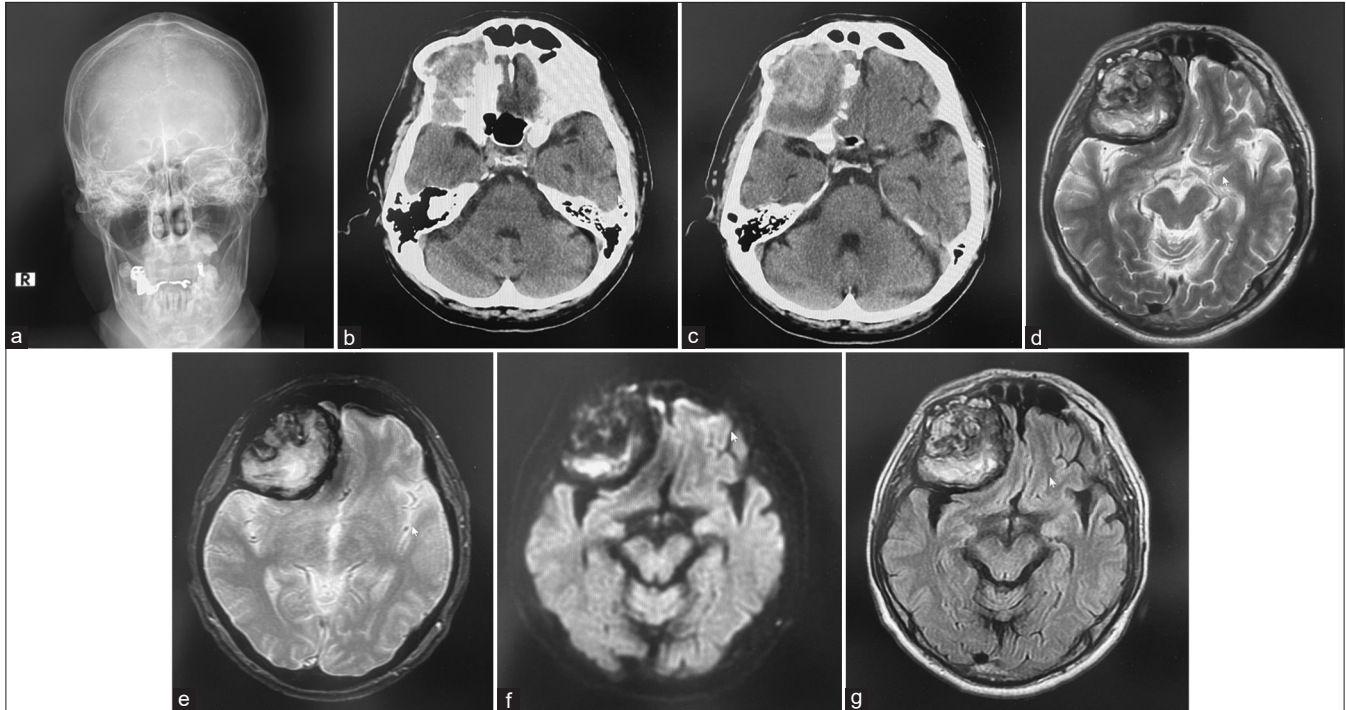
(a) Plain craniogram showed the destruction of the upper rim of the right orbit and the right sphenoid wing. (b and c) Brain plain CT examined in outpatient clinic revealed the mixed density lesion with partial high density and the right frontal skull-base destruction. (d) Brain plain magnetic resonance imaging (MRI) disclosed well-demarcated tumor-like lesion with heterogeneous mixed intensity in T2-weighted image, (e) Brain plain MRI disclosed well demarcated tumor-like lesion with heterogeneous mixed intensity in peripheral low intensity in T2 star image. (f) Brain plain MRI disclosed well-demarcated tumor-like lesion with heterogeneous mixed intensity partially high intensity in diffusion-weighted image. (g) Brain plain MRI disclosed well-demarcated tumor-like lesion with heterogeneous mixed intensity heterogeneous mixed intensity in fluid-attenuated inversion recovery image.
